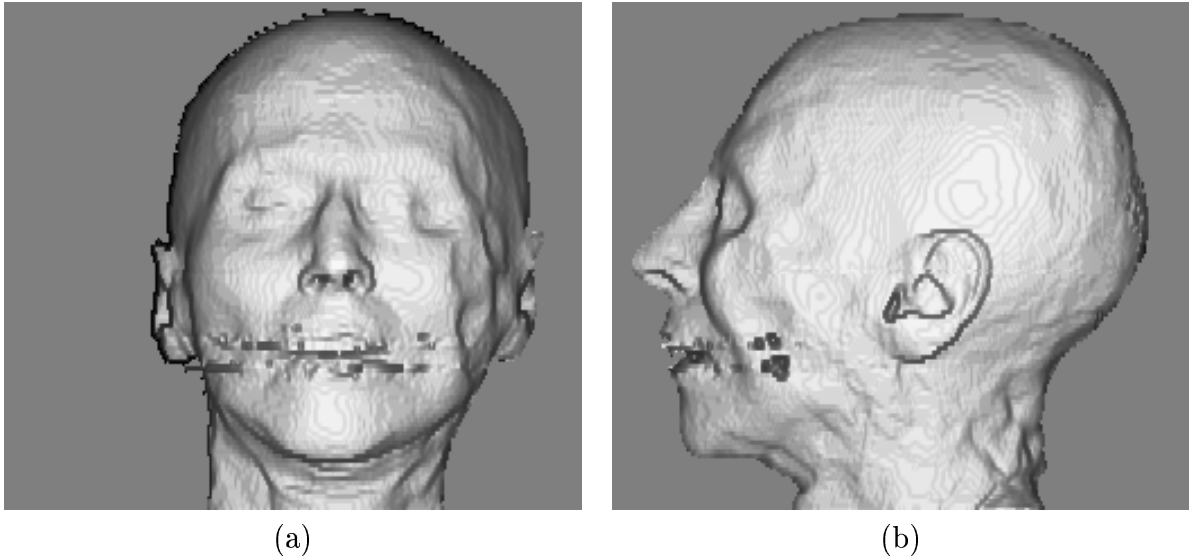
Three-dimensional rendering of the 3-D CT scan of the head in Figure 18.
